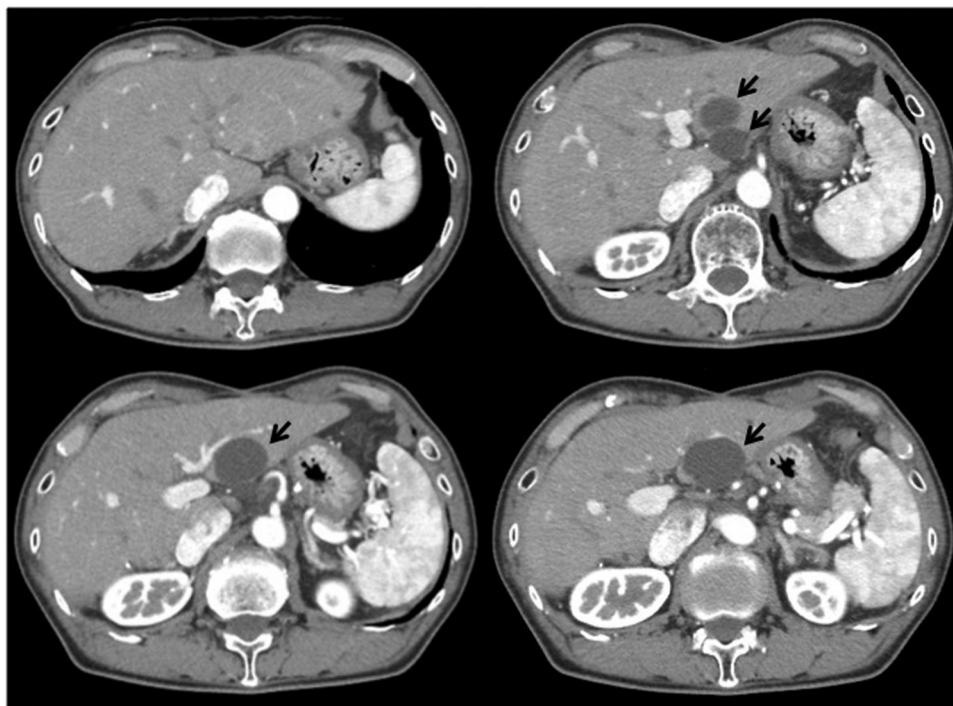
Contrast-enhanced computed tomography scan at 24 months after surgery. The patient is alive without recurrence. The arrows indicate liver cysts.
